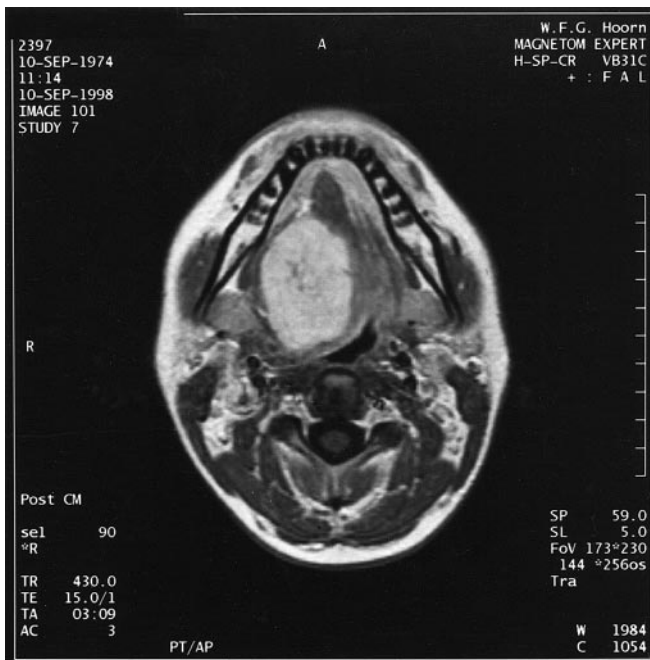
Axial T1-weighted magnetic resonance imaging with gadolinium enhancement showing a well-circumscribed, solid, hyperintense mass
